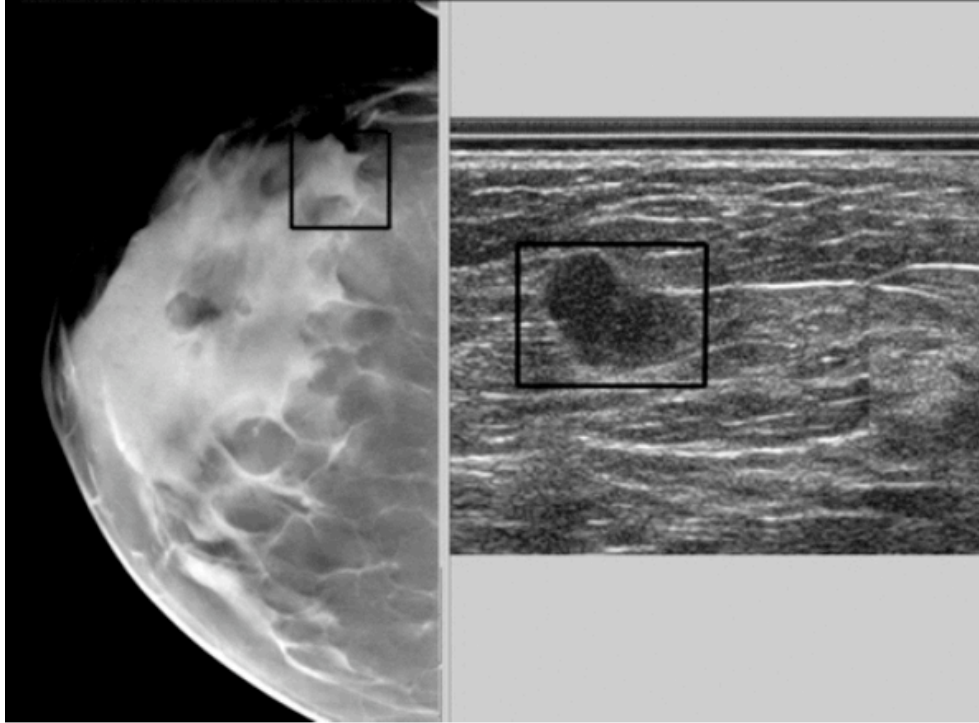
For this cancer case, a box was drawn around the lesion by the radiologist on the tomosynthesis image (in red), and transferred (in white) to the orthogonal automated ultrasound image on the right. Ultrasound image is at 2X magnification.
